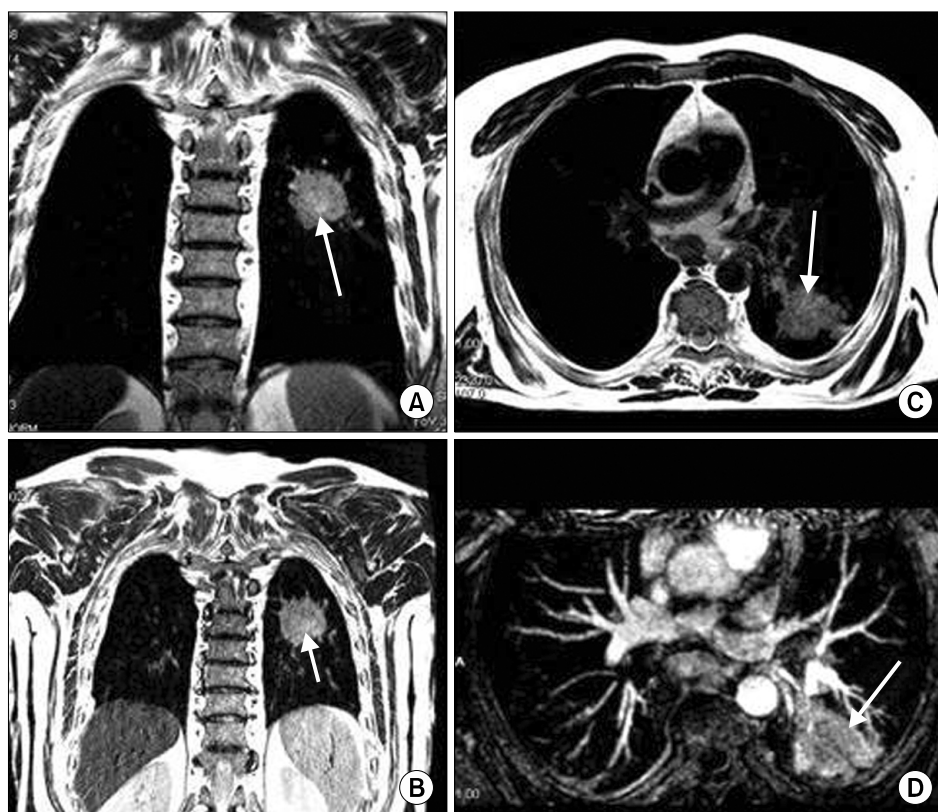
The image from a 61-year-old man. Peripheral cancer of the left lung. MRI of the thoracic cavity (arrows points to the tumor). (A) T2-weighted image in a coronal plane, thickness of a cut - 6 mm; (B) T2-weighted image in a coronal plane, thickness of a cut - 4 mm; (C) T2-weighted image in transversal plane, thickness of a cut - 6 mm; (D) T1-weighted image in transversal plane after the intra-venous introduction of contrast substance (Omniscan).
